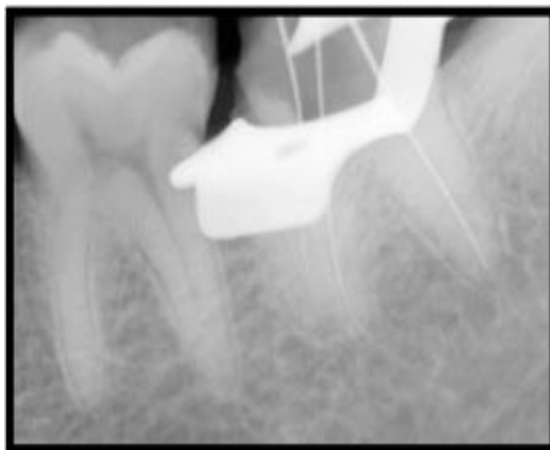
Working length radiograph of #37
